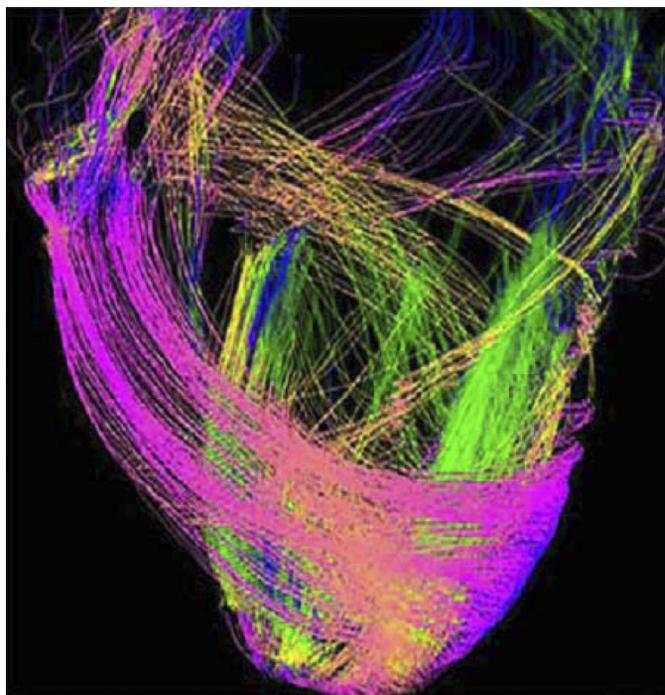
Muscle fibers in the LV through diffusion tensor MRI (DTMRI), provided to us by P. Helm. It shows how fibers have 2 dominant orientations.
